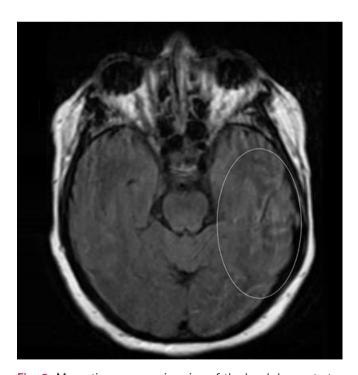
Magnetic resonance imaging of the head demonstrates non-suppression of fluid-attenuated inversion recovery signal (circle) around the left temporal and left occipital lobes suspicious for meningitis.
